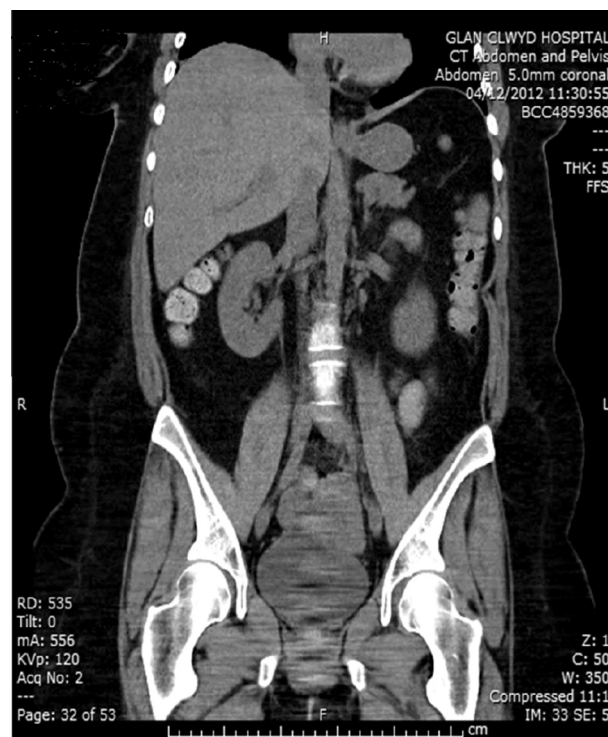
CT showing small bowel on the dome and anterior bladder wall.
